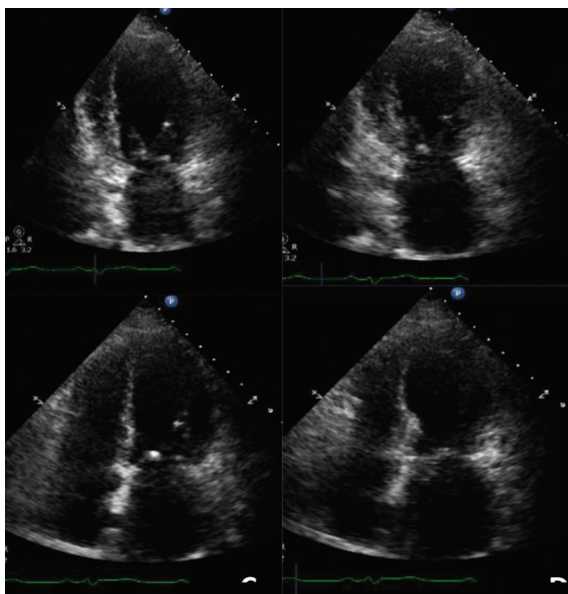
Echocardiogram in 4-chambers view and 2-chambers view at systole and diastole showing the apical akinesia, and left ventricular ejection fraction 30%, with classical apical ballooning, during the cardiomyopathy.
